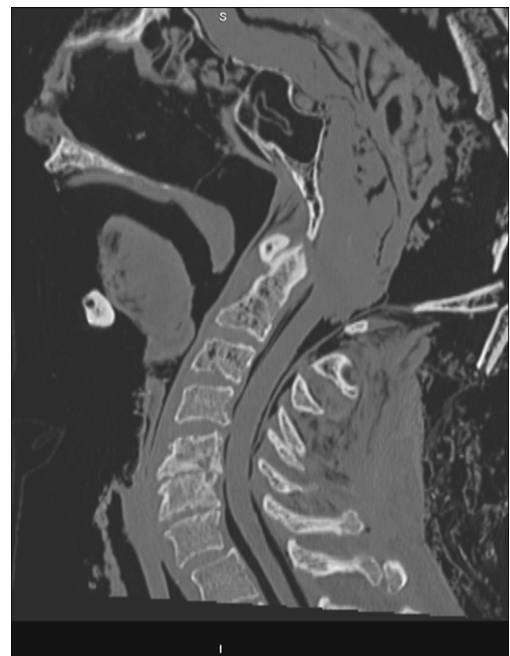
Sagittal MPR of the cervical spine in a severely burnt individual displaying severe osteoarthritis at C5,6 and C6,7. An age of >60 years was assigned to the individual based on the CT findings and was confirmed on final analysis.
